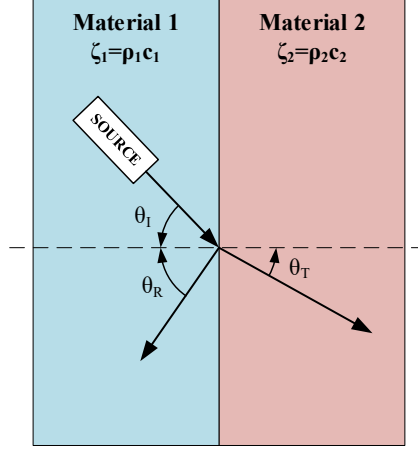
Phenomenon of reflection and transmission of ultrasonic waves at the interface between two different materials.
